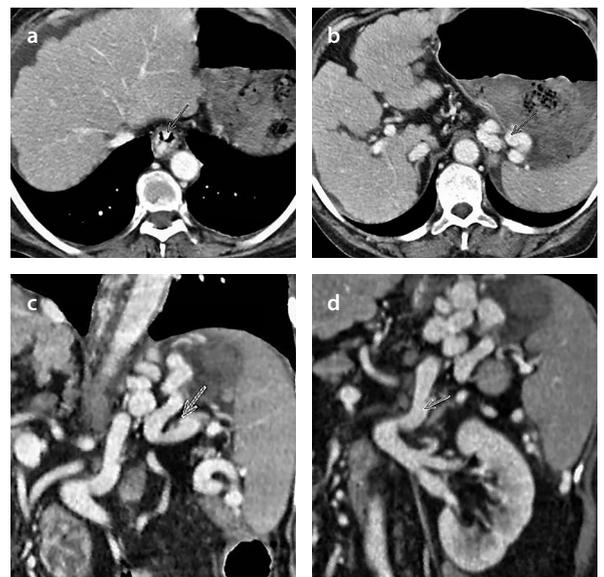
a-d. Contrast-enhanced computed tomographic scan axial images a and b show esophageal (arrow in a) and gastric (arrow in b) varices; coronal oblique images c and d show gastric varices fed from a short gastric vein (arrow in c) and draining via the left renal vein (arrow in d indicates drainage vein)
